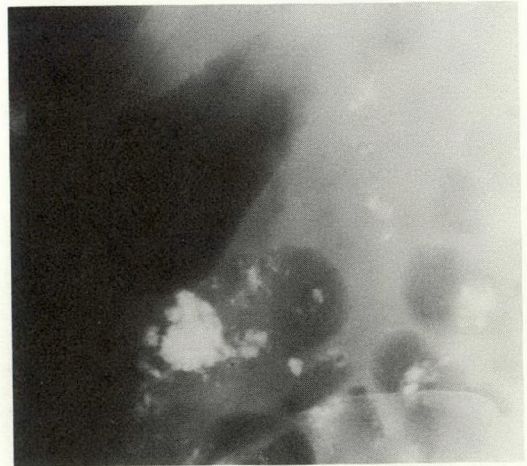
Cas no 1. Radiographie simple de l'abdomen, qui montre une vésicule biliaire pleine d'air.
